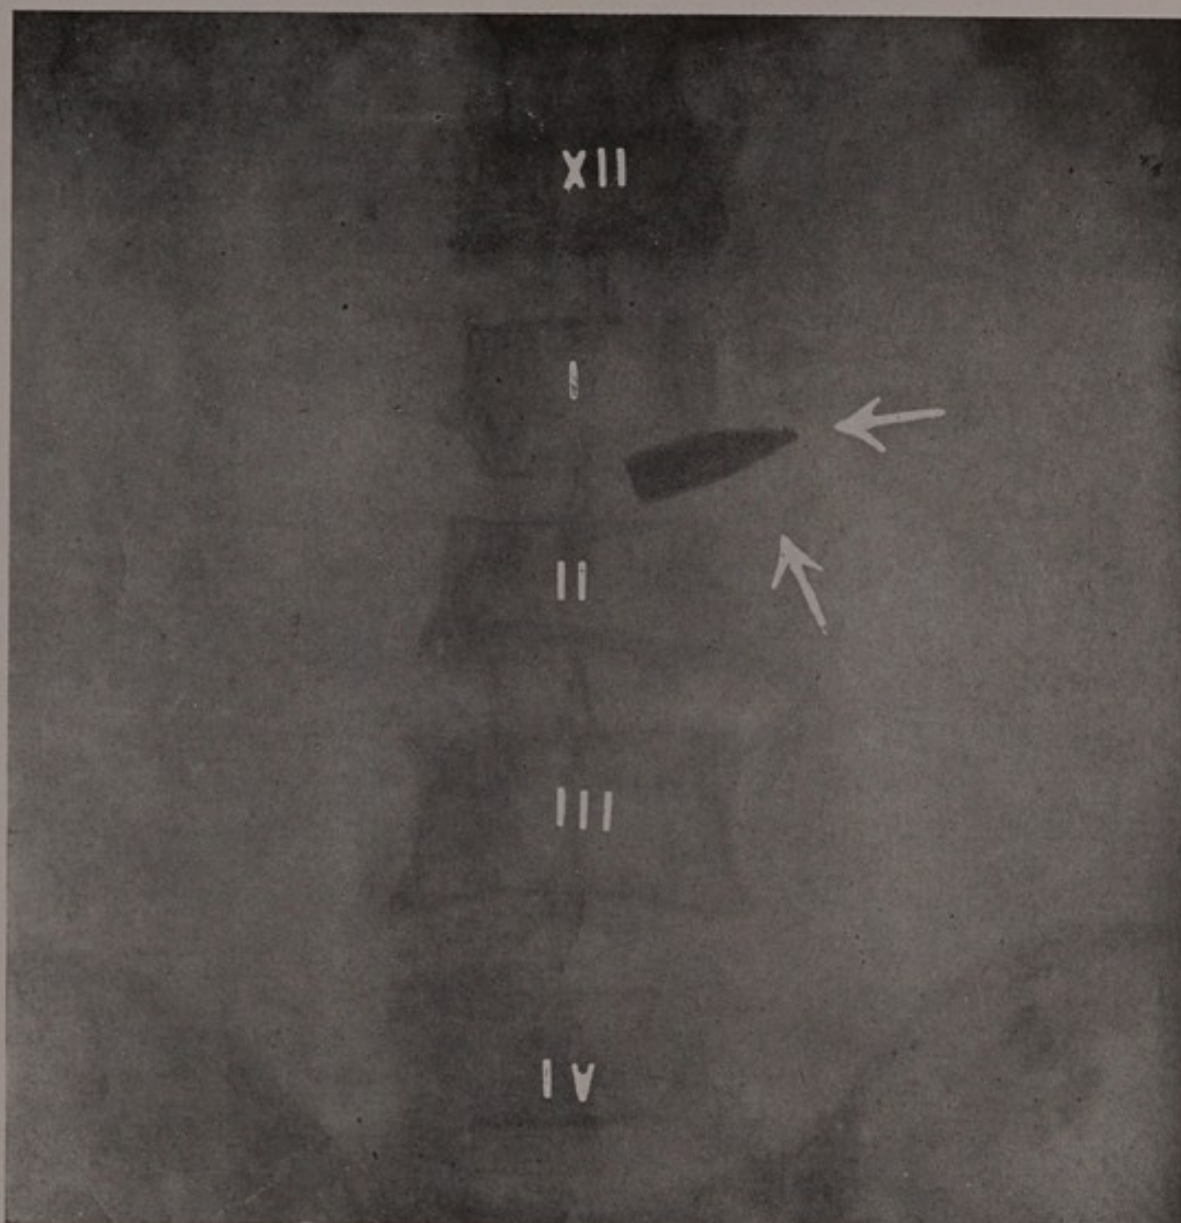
X-ray of bullet between the first and second lumbar vertebrae. (Taken by Dr. Jaugeas of the Ambulance of the American Hospital of Paris, and loaned to me by Dr. Richard Derby of New York City.)
